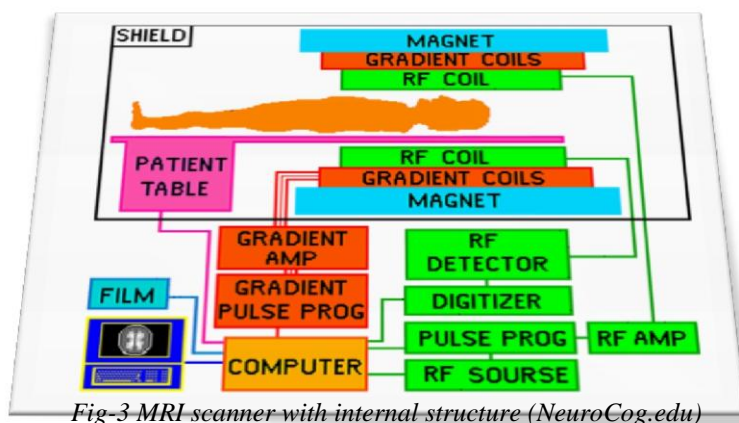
MRI scanner with internal structure (NeuroCog.edu)
